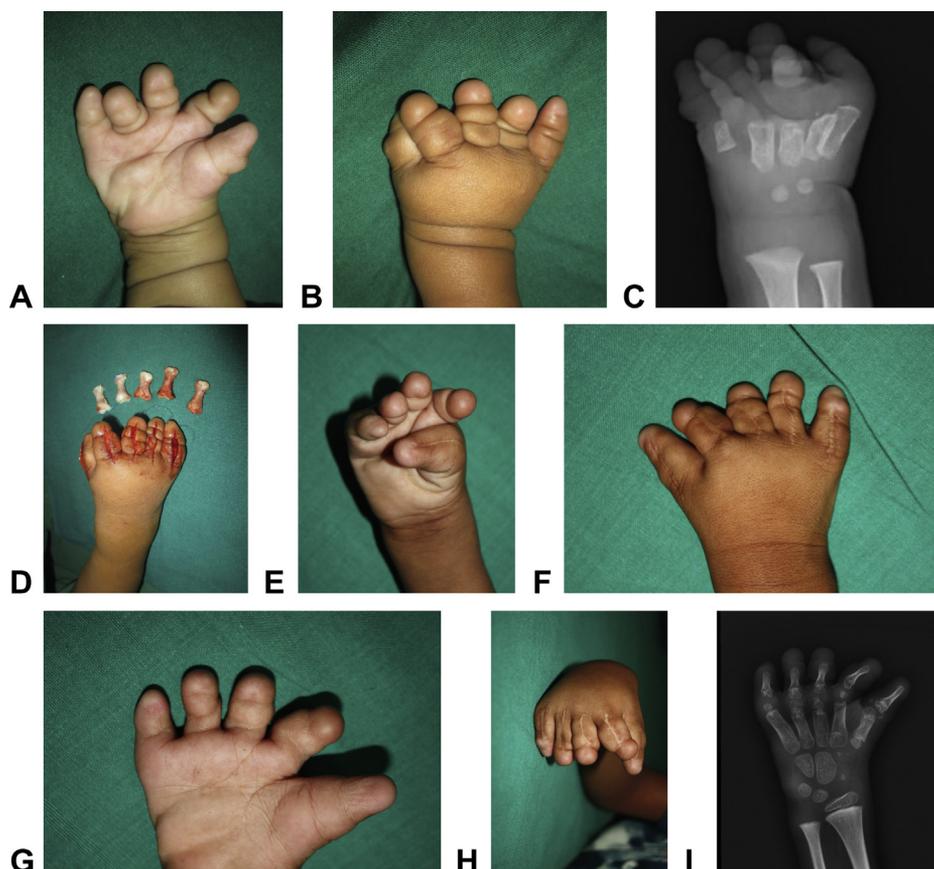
A, B Symbrachydactyly in a child at 1 year and 8 months with absent phalanges and redundant soft tissue. C Preoperative radiograph. D Harvest of 5 proximal phalangeal grafts, from the third and fourth toes of the left foot and the third, fourth, and fifth toes of the right foot. E–H Follow-up after 4 years and 5 months, at the age of 6 years and 1 month. I Final radiograph.
